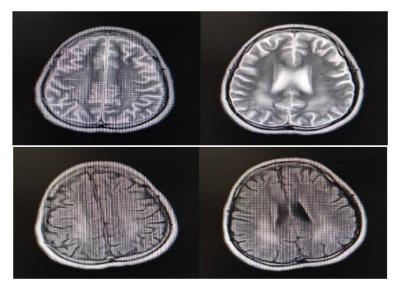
Hyperintense lesion on periventricular, white matter bilateral, and deep white matter on T2W, and FLAIR (axial plane)
